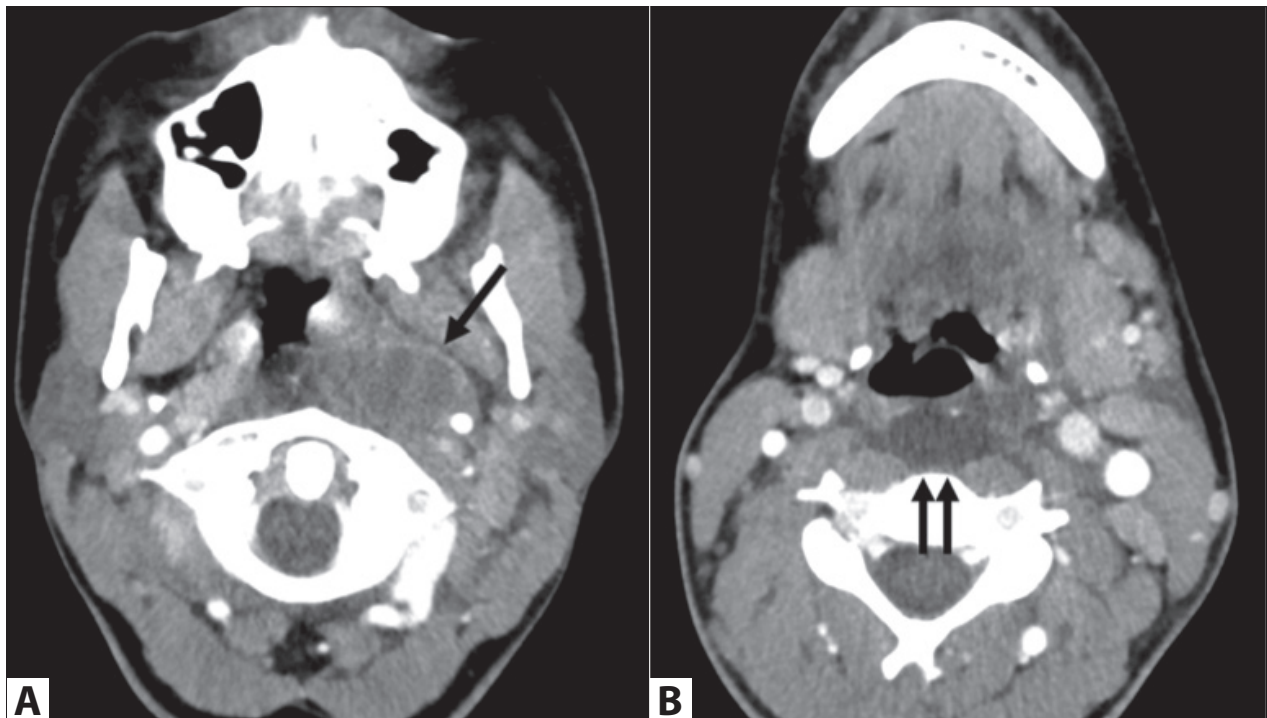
Axial contrast neck CT slices of the oropharynx A. and hypopharynx B.
